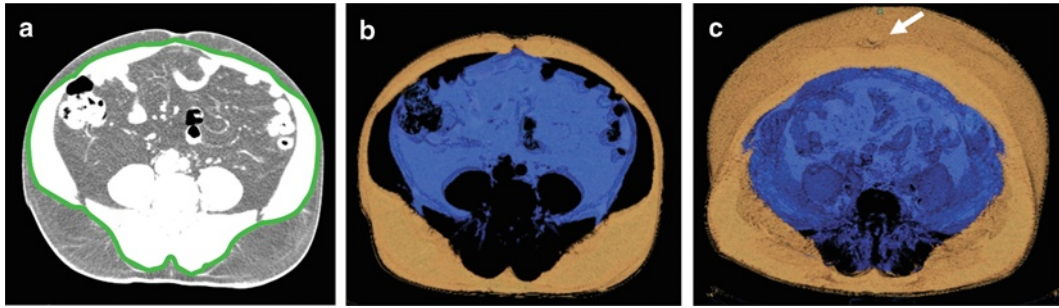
VAT and SAT quantification using CT. *For the black and white image:* Single cross-sectional CT scan at the umbilical level (*panels A and B*) and a 12.5-cm wide volumetric data set (*panel C*). The inner border of subcutaneous abdominal adipose tissue (SAT) is traced automatically (*black*). The SAT (*light gray*) area is calculated by subtracting the visceral abdominal adipose tissue (VAT) (*dark gray*) area from the total cross-sectional fat area or total abdominal fat volume. The *arrow* points to the umbilicus in the three-dimensional data set. SAT subcutaneous adipose tissue, VAT visceral adipose tissue. *For the color image:* Single cross-sectional CT scan at the umbilical level (*panels A and B*) and a 12.5-cm wide volumetric data set (*panel C*). The inner border of subcutaneous abdominal adipose tissue (SAT) is traced automatically (*green line*). The SAT (*orange color*) area/volume is calculated by subtracting the visceral abdominal adipose tissue (VAT) (*blue color*) area/volume from the total cross-sectional fat area or total abdominal fat volume. The *arrow* points to the umbilicus in the three-dimensional data set. SAT subcutaneous adipose tissue, VAT visceral adipose tissue
